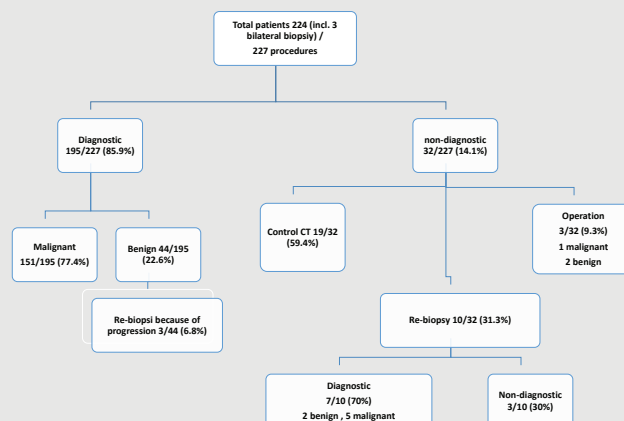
Abbreviations: CT = computed tomography; IQR = inter quartile range.
